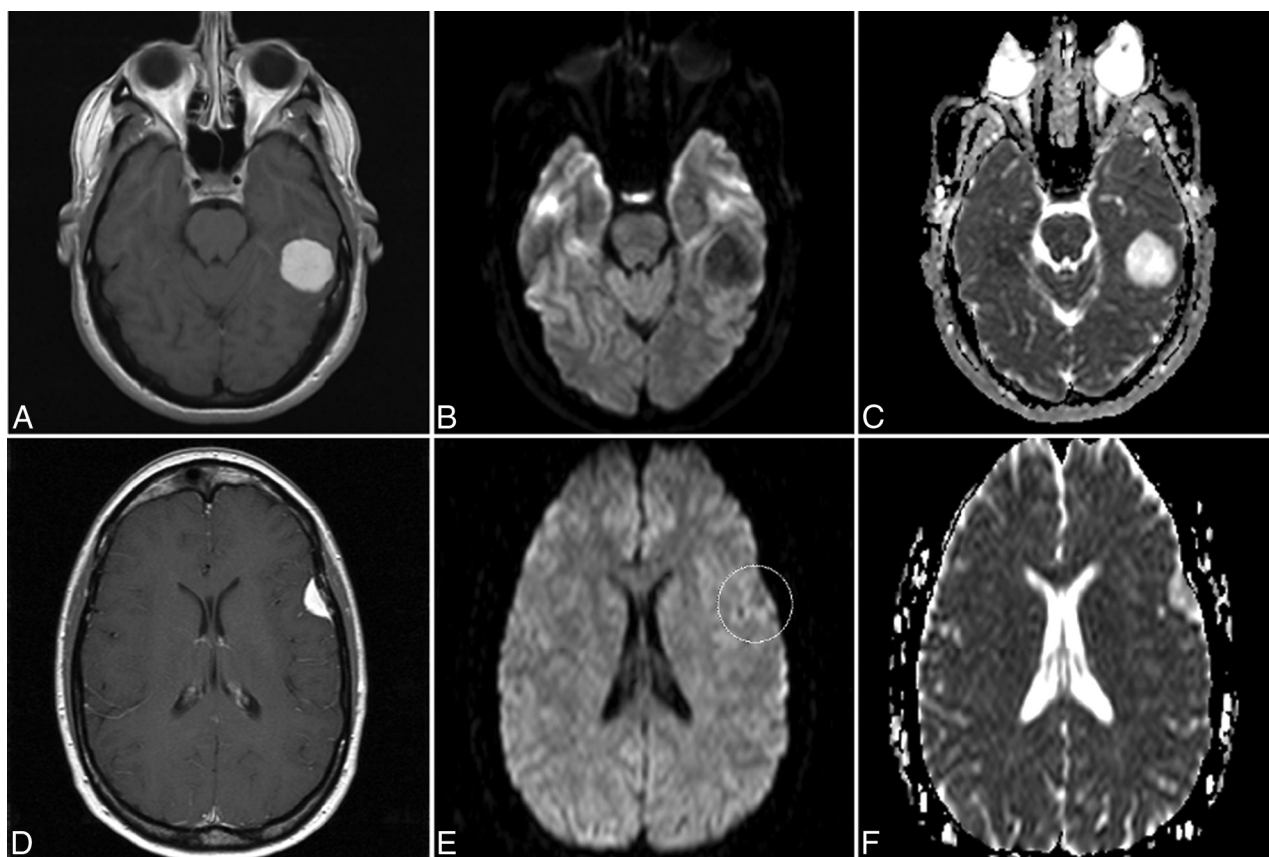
Chordoid meningioma shows facilitated diffusion. *A*, Postcontrast T1-weighted image showing avid homogeneous enhancement of a left temporal chordoid meningioma. *B*, DWI shows hypointensity of this chordoid meningioma. *C*, ADC map corresponding to the tumor shown in *B* depicting hyperintensity of the meningioma with an ADC value of 2.11 and an NADC ratio of 2.93, which represent increased diffusion. *D*, Postcontrast T1-weighted image of a different patient shows avid homogeneous enhancement of a left frontal convexity chordoid meningioma. *E*, DWI of this tumor shows isointensity to slight hypointensity of the tumor. *F*, ADC map corresponding to tumor shown in *E* shows increased signal of the meningioma with an ADC value of 1.47 and an NADC ratio of 1.99, which are consistent with facilitated diffusion.
